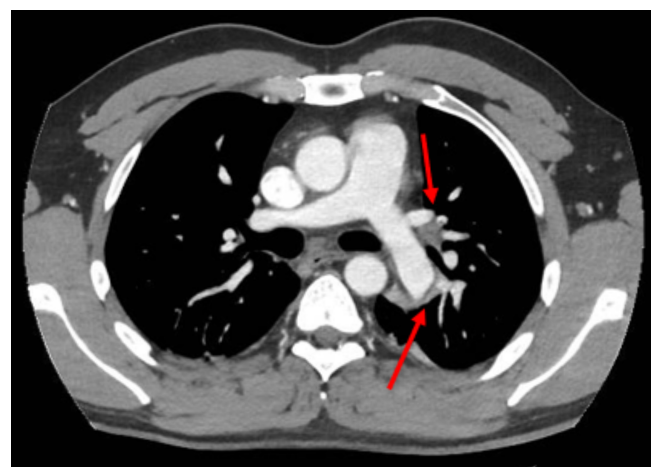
CT scan of the pulmonary embolism of the left lobar artery (red arrows) performed after 24 hours of NIV. Note: CT: Computed tomography; NIV: Non-invasive ventilation.
